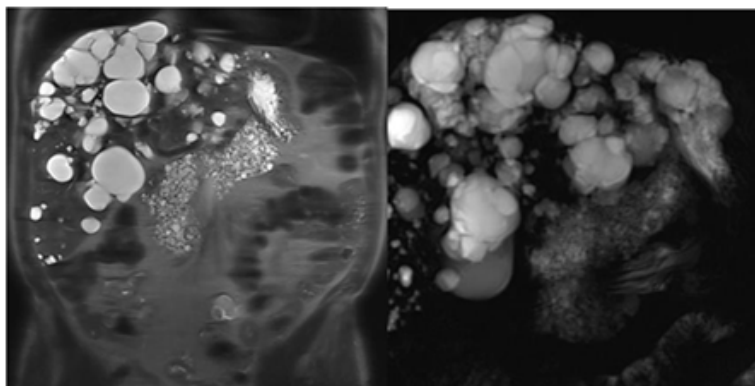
MRI findings of case 2
